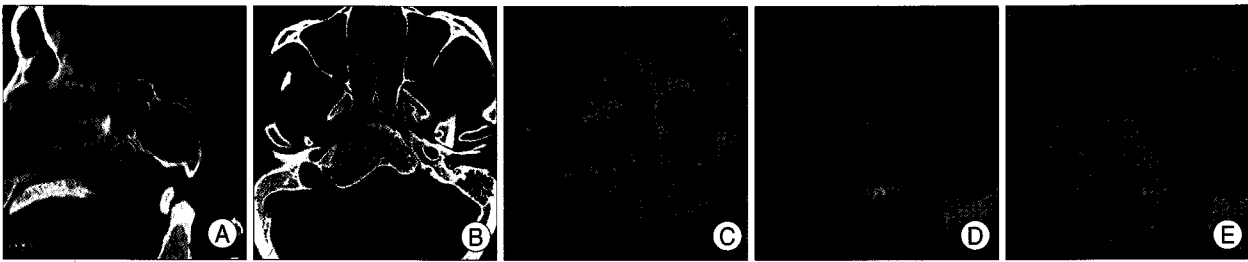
Computed tomography scans and magnetic resonance images of a young adult with clival fibrous dysplasia. Note the intact cortical tables and the ground-glass appearance (A and B). The lesion is partially hyperintense on T2-weighted image (C), and hypointense and moderately enhanced on T1-weighted images (D and E).
